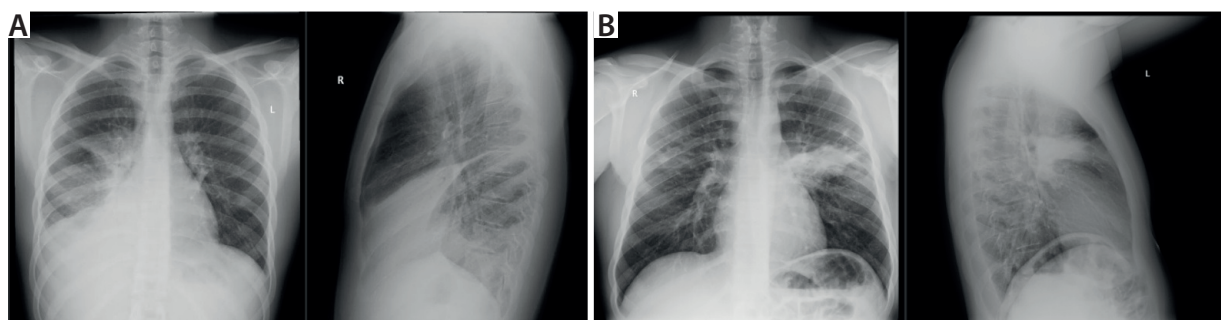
Patients' chest X-rays. Case 1 showing features of lobar pneumonia (A), and case 2 revealing atelectasis-inflammatory changes in the left lung (B)
